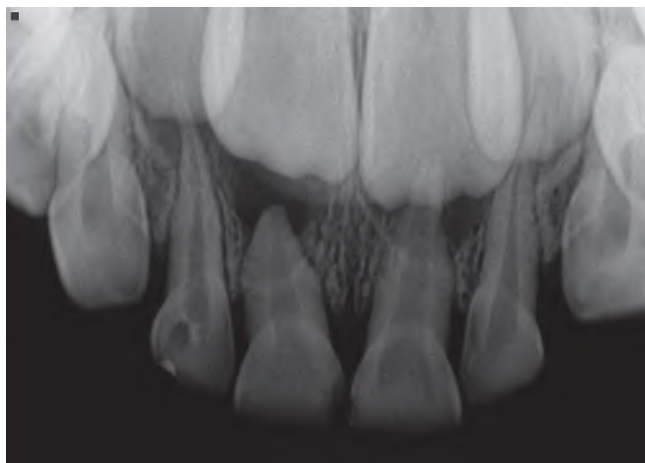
Anterior maxillary periapical radiograph showing a periapical radiolucency and atypical root resorption associated with the primary right central incisor.
